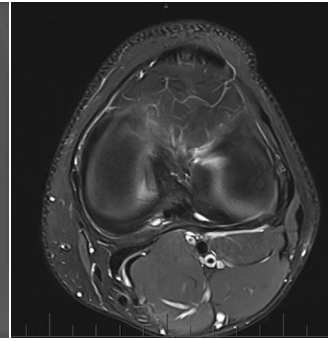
Initial Baker's cyst observed on T2-weighted axial MRI scan - pre-aspiration.
